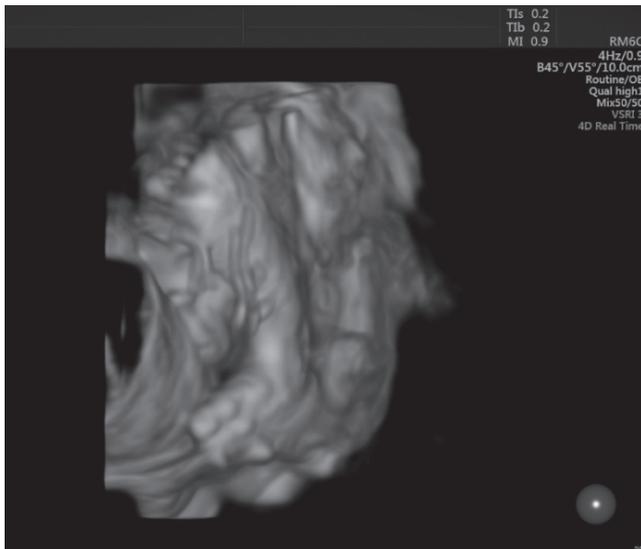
Three-dimensional ultrasound evaluation of the fetal lower limbs revealed left clubfoot.
